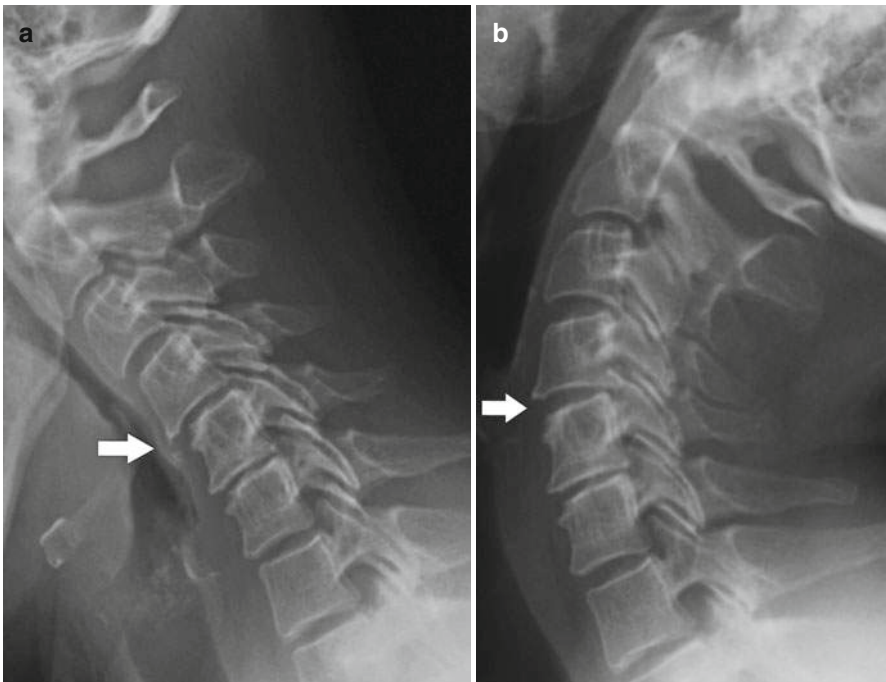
Cervical spine instability. Cervical spine X-ray lateral flexion (a) and extension (b) views show anterolisthesis of C4 on C5 (arrows) with flexion but not extension, suggesting ligamentous injury
